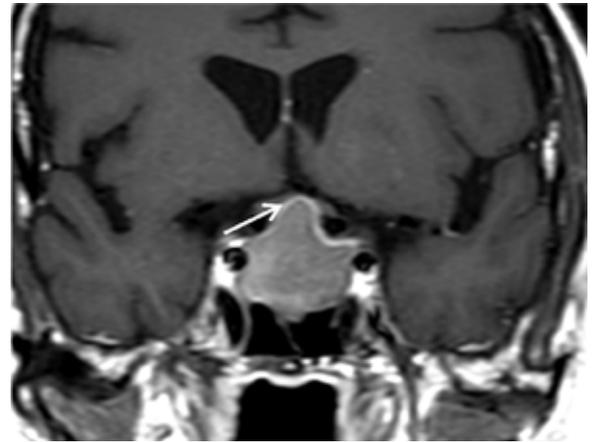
Contrast MRI pituitary showing compression of the optic chiasm by a pituitary macroadenoma prior to surgery
